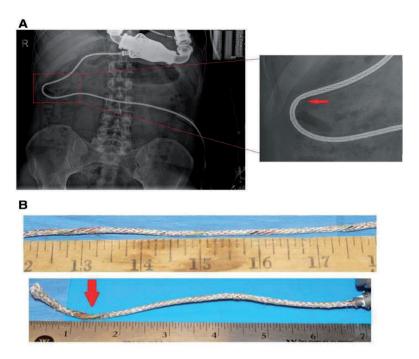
A X-ray of internal part of the driveline of a 54-year-old male (Patient no. 7 in table 3), who received a LVAD because of progressive heart failure, which originated from a myocarditis. Twenty-six months after LVAD implantation he experienced low voltages. Initially it was thought to be a software problem and his controller was exchanged. However, he presented himself, 29 months after LVAD implantation, with a pump stop during the night, which was position dependent. X-ray of the internal part of the driveline showed irregularities in the C-shape section. Because of the pump stop and the irregularities of the driveline, his LVAD and driveline was exchanged. B Driveline damage externally observed.
